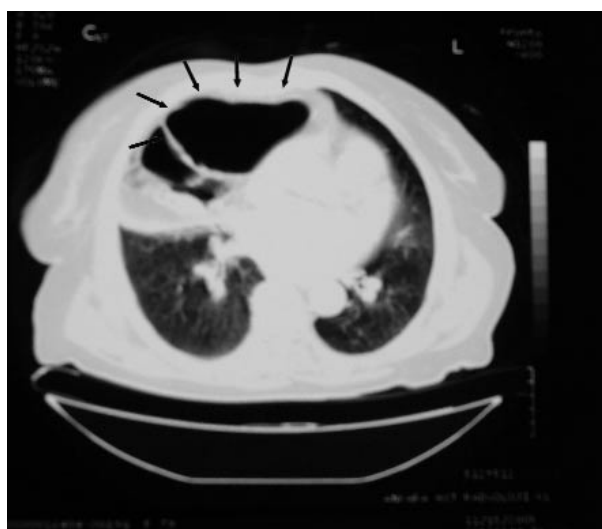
CT scan of the thorax indicating diaphragmatic eventration.
